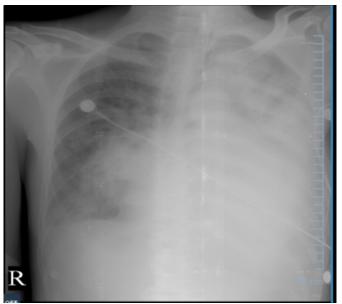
Chest X-ray shows pneumonia with bilateral pleural effusion.
